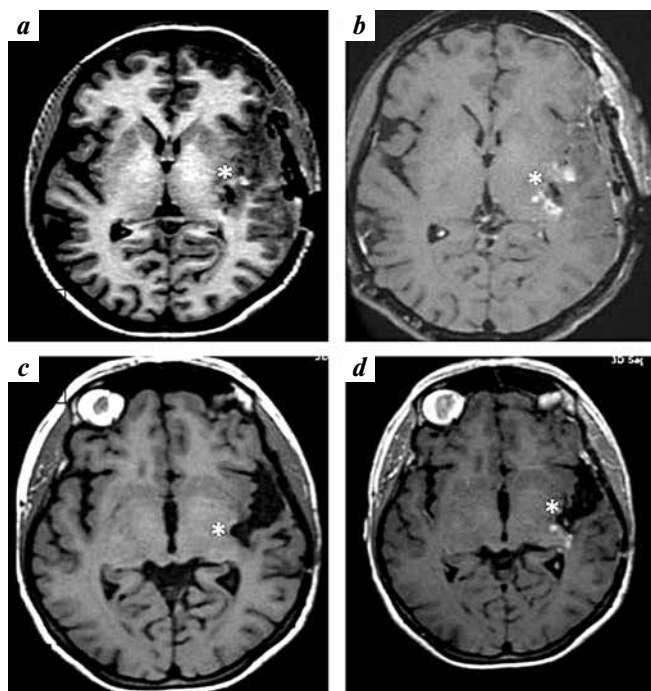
Clinical case 2. Brain magnetic resonance imaging of patient: a, b – on 3rd postoperative day: the residual fragment (marked with stars) on T1-weighted images without (a) and with (b) contrast enhancement; c, d – 8 months after surgery: residual fragment (marked with stars) on T1-weighted images without (c) and with (d) contrast enhancement. Without dynamics
